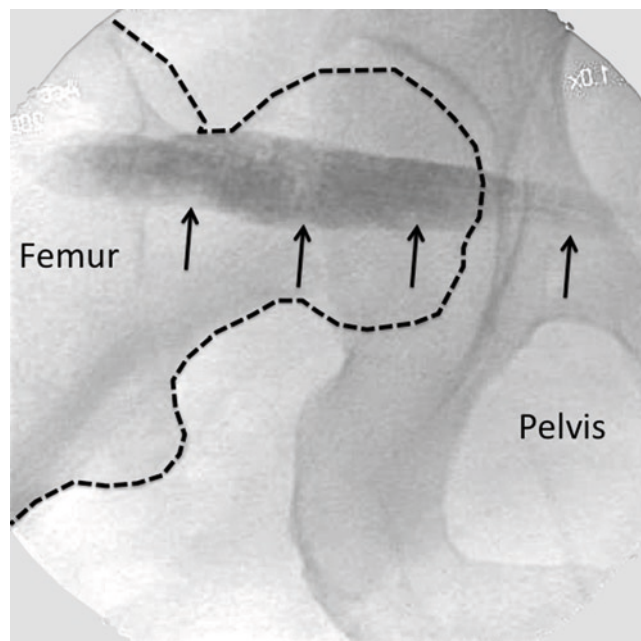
Radiographic contrast (indicated by *line arrows*) outlining the piriformis muscle. Reproduced with permission from USRA (www.usra.ca).
